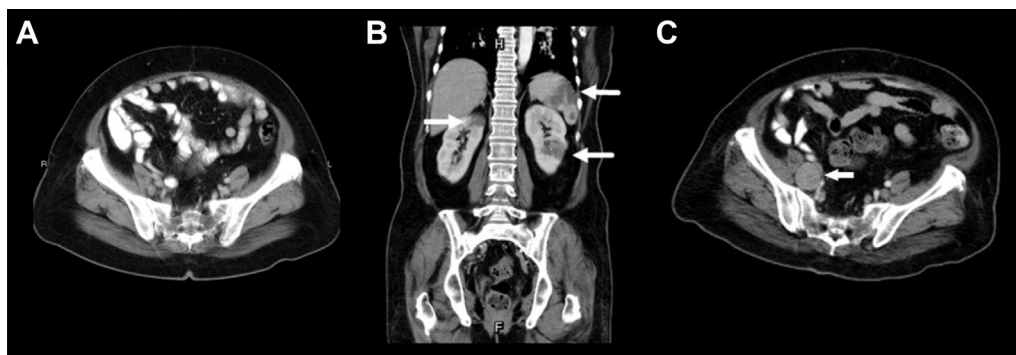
Contrast-enhanced computed tomography revealed (A) no evidence of para-aortic lymph node enlargement or ascites, but did show (B) multiple low-density lesions in the spleen and kidneys and (C) enlarged nodes (size $< 2.7 \text{ cm}$) in the right pelvic cavity, findings consistent with recurrent tumor with embolic infarcts. The ovary and uterus were removed.
